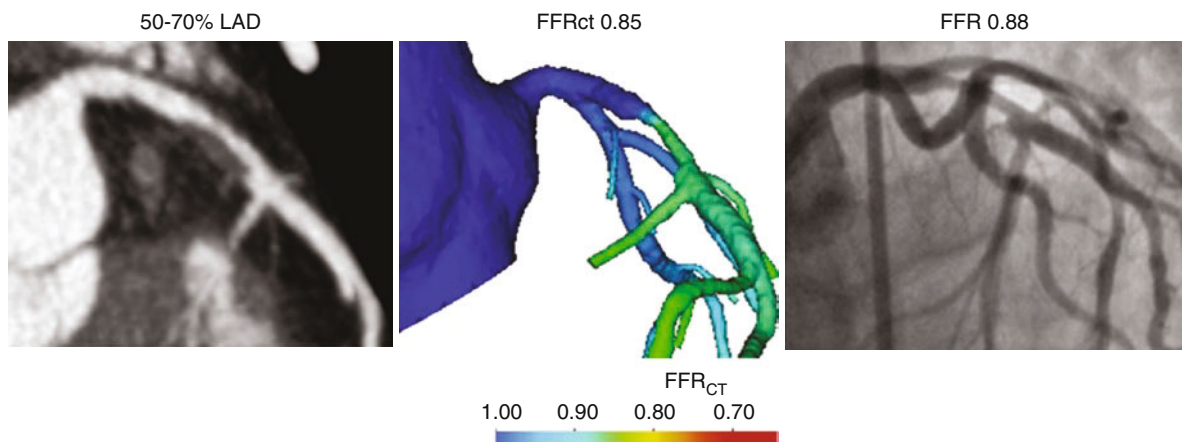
Use of  $FFR_{CT}$  in intermediate-severity stenoses. This 66-year-old woman had recent onset of typical angina symptoms. She had no cardiac risk factors. A CTA demonstrated 70–90% stenosis in the LAD
